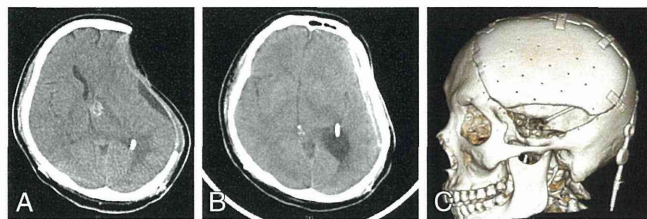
A, Computed tomographic scan performed 2 months after the first operation. B, Postoperative CT scan showed no low-density areas around the fascia lata or artificial bone. C, Postoperative three-dimensional CT scan of the skull and solid-type artificial bone.
